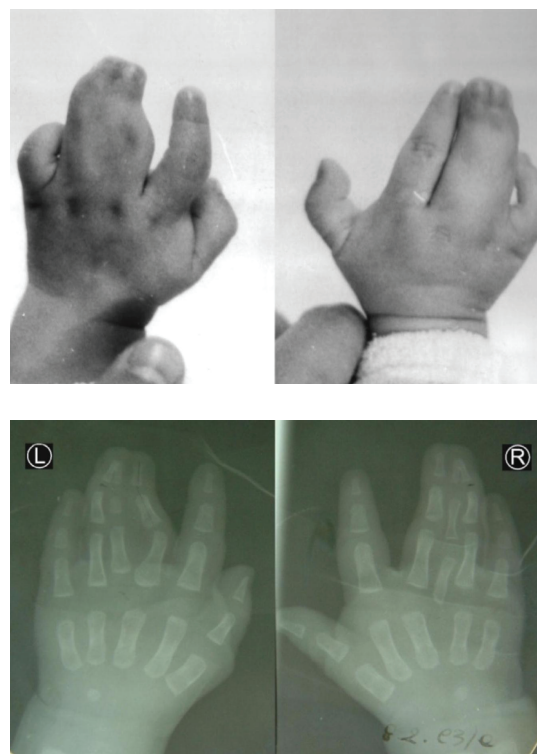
Macroscopic and radiographic images of patient's hands at 8 months old.
